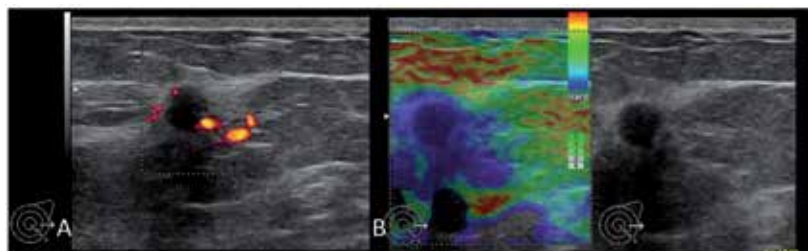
Doppler US reveals a hypoechoic round lesion with partially angulated margins and peripheral vascularity (A). On strain elastography (B), the entire lesion and its surrounding parenchyma were shaded blue (TS 5). The lesion was upgraded from BI-RADS 4B to BI-RADS 4C after the elastography criterion was added.
